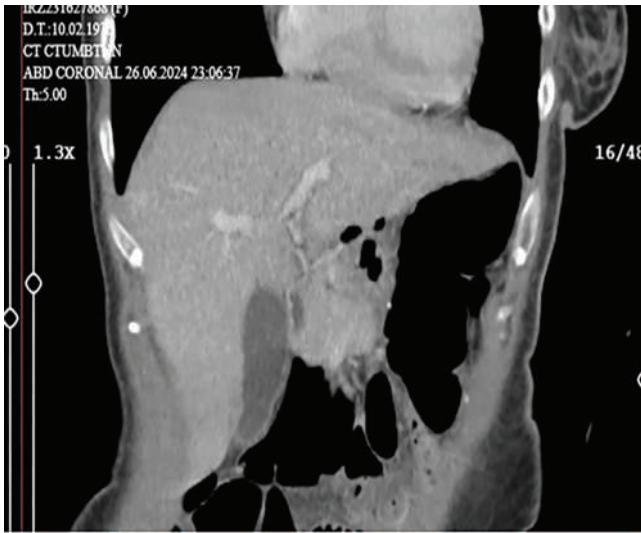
Case 1: preoperative contrast-enhanced CT image (coronal). Thin fluid-air levels consistent with perforation are observed in the hepatogastric region, along with localized millimetric free air foci at the level of the hepatogastric ligament and adjacent to the lesser curvature of the stomach.
